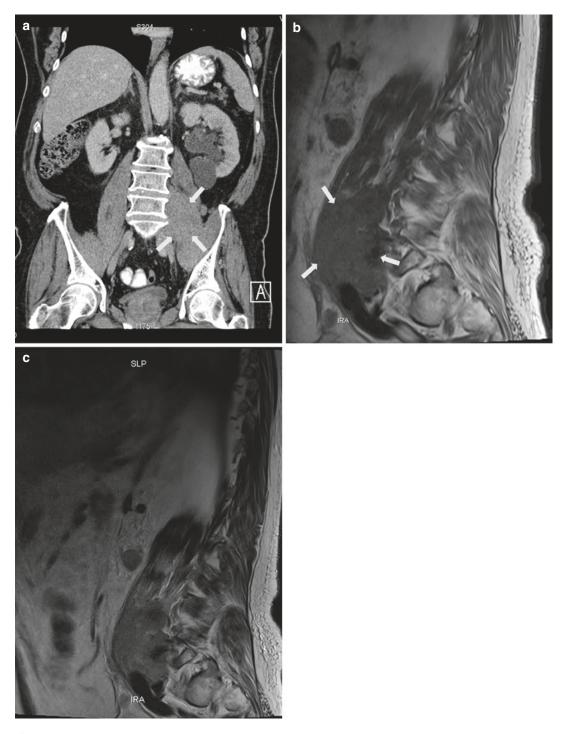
Retroperitoneal lymphoma in 81-year-old male. (a) Coronal CT of the abdomen after intravenous administration of jodium contrast. Mass at the left psoas region, isointense with muscle (*arrows*). No destruction or major disk space narrowing at the lumbar segments is present. (b) Sagittal T1-WI of the lumbar spine demonstrating an isointense mass compared to muscle involving multiple lower lumbar segments (*arrows*). (c) Sagittal T2-WI of the lumbar spine demonstrating nonhomogeneous slight hyperintense mass compared to muscle tissue
